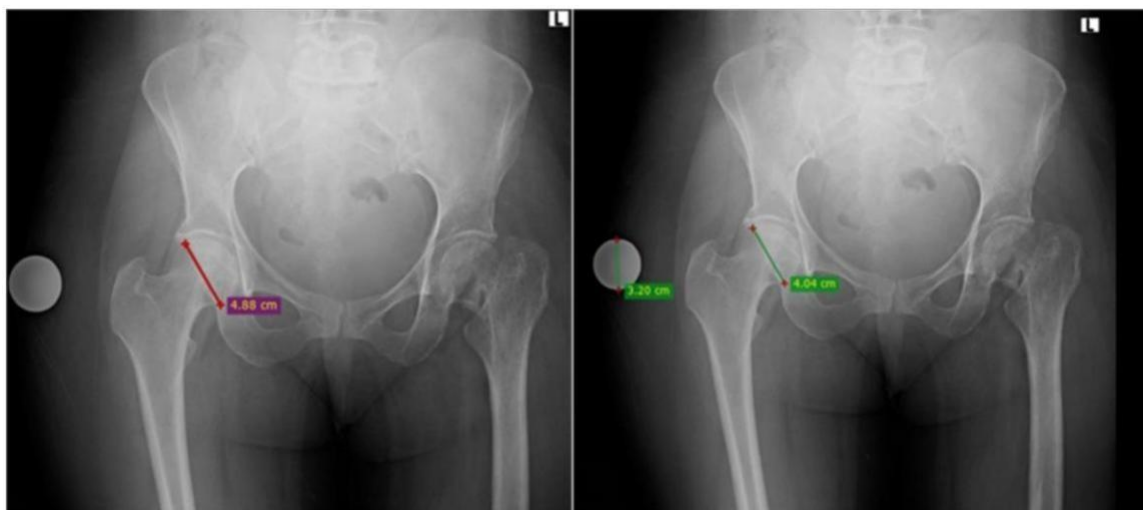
direct X-ray measurement of femur head
